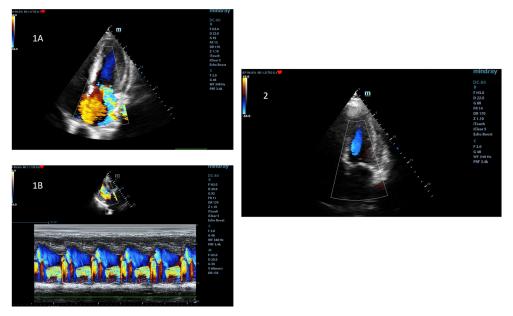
b.12. Severe holosystolic mitral regurgitation before surgery (image 1A: color Doppler, 4-chambers view; 1B: color M-Doppler) and no mitral regurgitation after mitral valvuloplasty (imgage 2: color Doppler, 4-chambers view)
